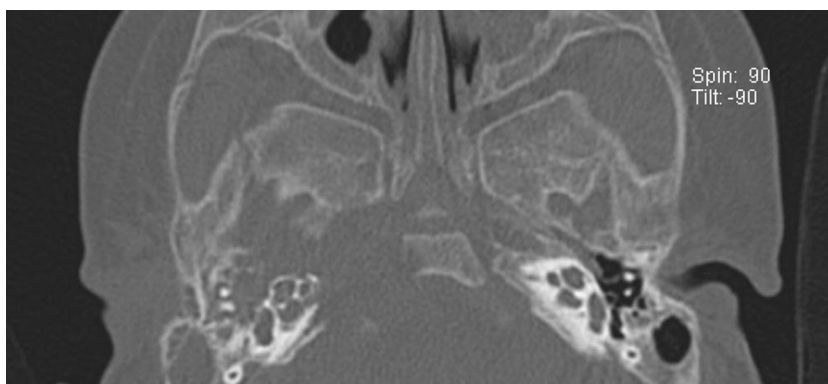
Computed tomography of the temporal bone. An expansile osteolytic bone tumor located in the right central skull base, involving the right temporal bone and clivus, and extending to the middle ear cavity and inner ear structures. Suppurative right otomastoiditis with multifocal outer table erosions was also observed.
